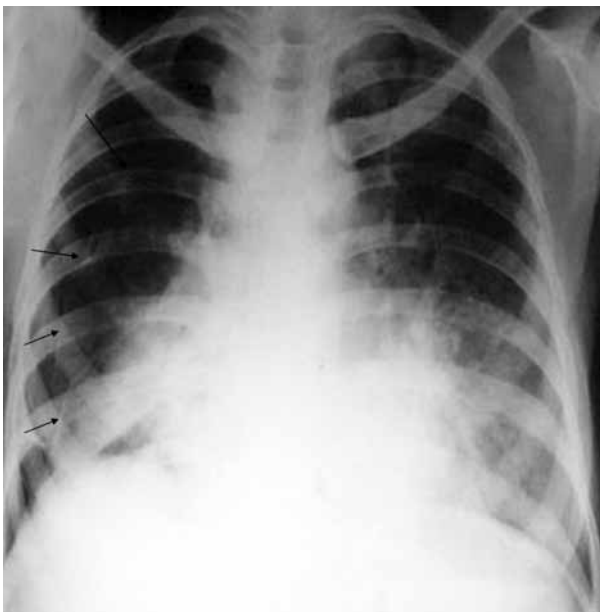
Chest X-ray showing the second right pneumothorax (arrows).
